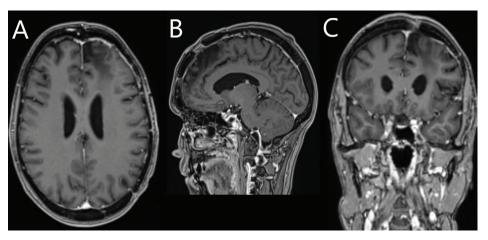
(A, B and C). MRI of the brain with contrast (gadolinium). Shows axial, sagittal, and cortical sections of the cerebellar mosaic in T1 sequence showing no meningioma recurrence
